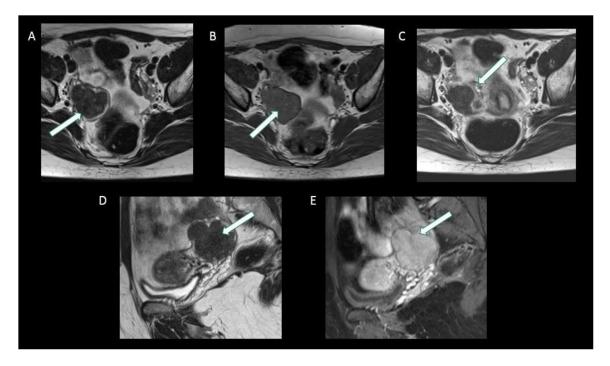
(A) Axial T2-weighted image showing well defined lobulated hypointense lesion (white arrow) in right ovary. (B). Axial T1-weighted images showing lobulated iso to hypointense lesion (white arrow) in right ovary. (C) Axial T2-weighted image showing medial displacement of the ovarian parenchyma containing multiple tiny T2 hyperintense follicles (white arrow). (D) Sagittal T2-weighted image showing defined lobulated hypointense lesion (white arrow) in right ovary. (E) Sagittal postcontrast image showing homogenous contrast enhancement of the lesion (white arrow) similar as that of uterine myometrium.
